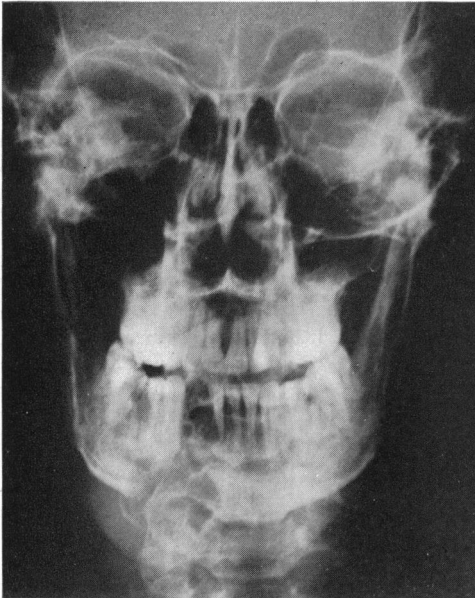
Roentgenogram showing a cyst of the mandible with a pathologic fracture (Case 2).
